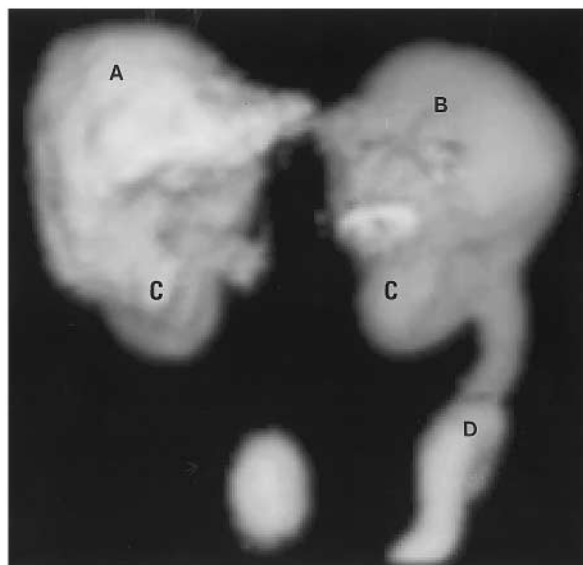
A three-dimensional rendered SPECT somatostatin receptor scintigraphy image collected 24 h post injection. Pathological accumulation of [¹¹¹In-DTPA-O-Phe¹]-octreotide is shown in the central part of the abdomen, indicating the presence of the primary midgut carcinoid tumor and the mesenteric metastasis. A: liver; B: spleen; C: kidney; D: activity in the left colon.
